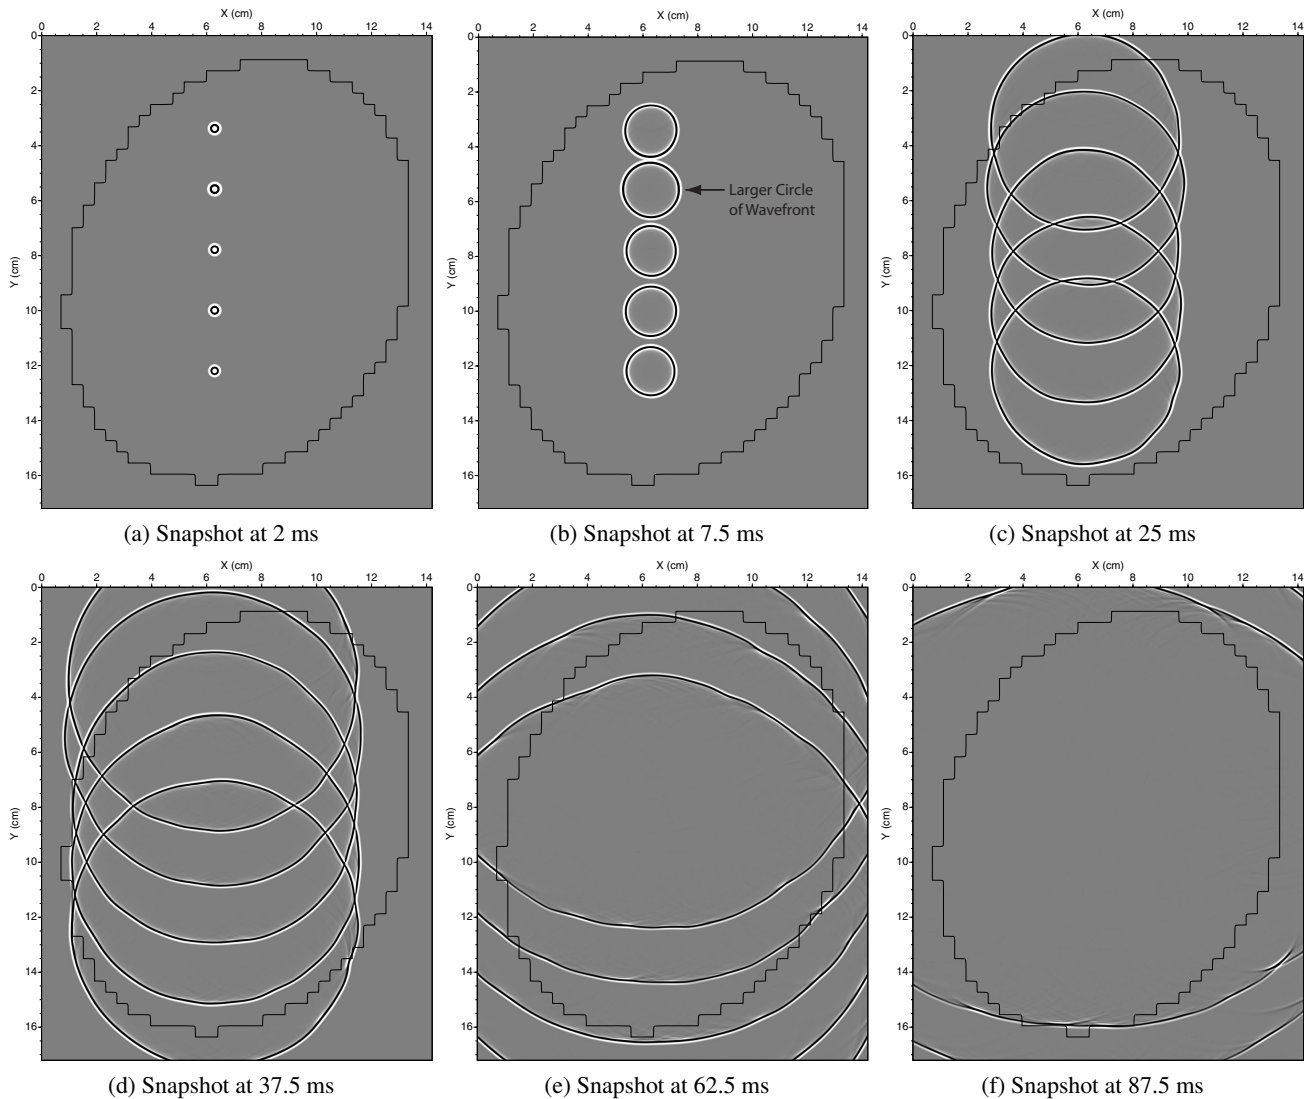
Snapshots of ultrasonic-wave propagation from the five point sources located within the breast model in Figure 1 demonstrate wavefront distortion and scattering by heterogeneities of the breast. The solid line in each panel indicates the location of the breast. Note that the larger circle indicated by the arrow in (b) is due to the higher-sound-speed tissue around that region.
